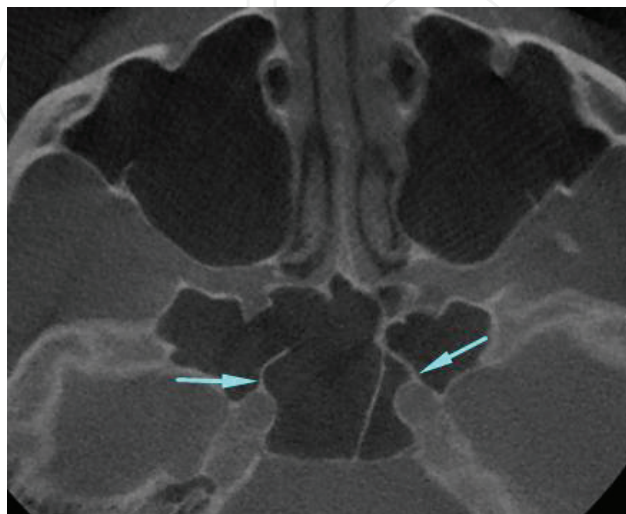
Axial CBCT images. Sphenoid sinus septum adheres to the ICA wall bilaterally.
